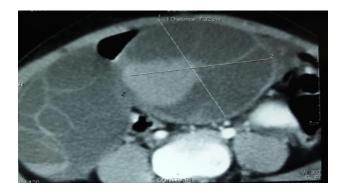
CT scan showing multicystic ovaries.
